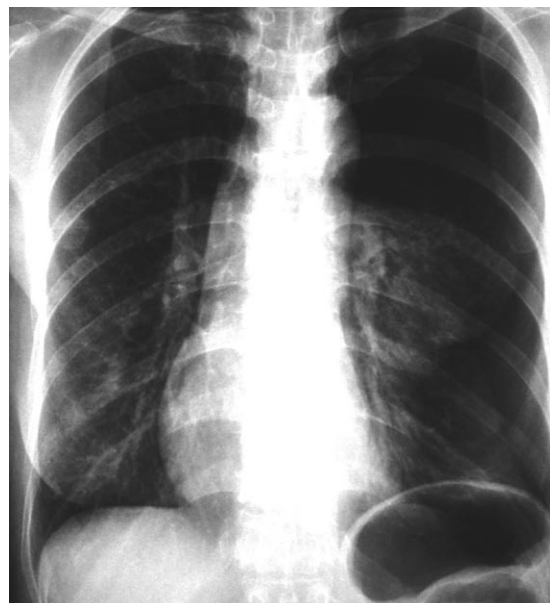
Chest radiograph shows a left-sided tension pneumothorax with shift of the mediastinum and trachea to the right. A small right apical pneumothorax is present.
